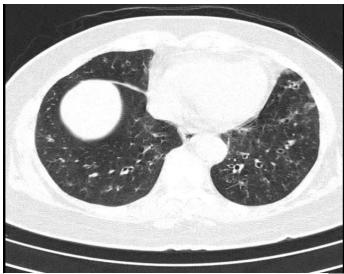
CT scan showing bilateral left lower lobe bronchiectasis and left upper lobe bronchiectasis.
